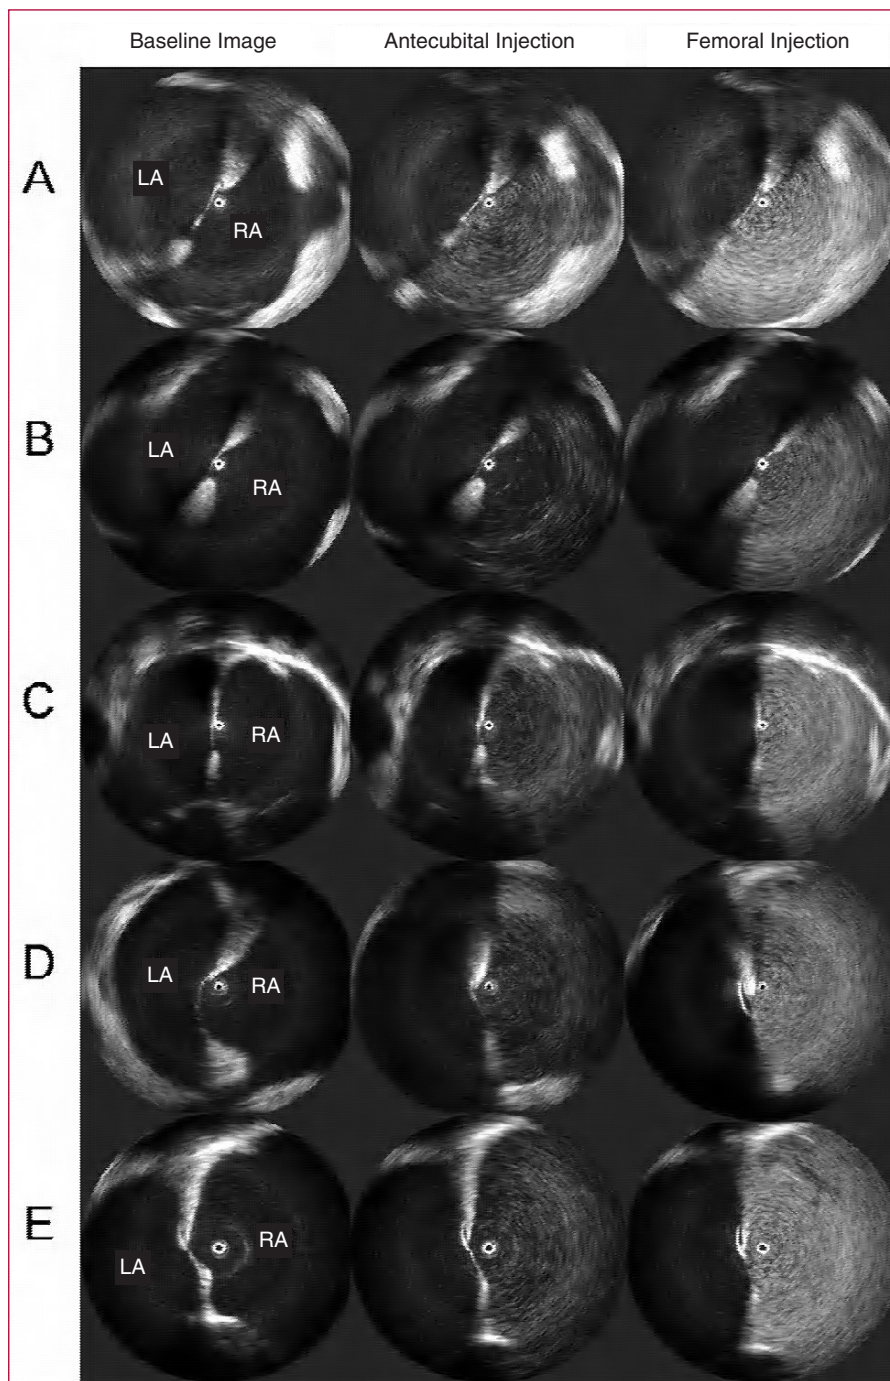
Intracardiac ultrasound images. Rows A-E: representative cases. First column: baseline image of intracardiac echocardiography. Second column: echo contrast of right atrium after antecubital injection of agitated saline. Third column: echo contrast of right atrium after femoral injection. Note that opacification is more intense after femoral versus antecubital injection. LA indicates left atrium; RA, right atrium.
